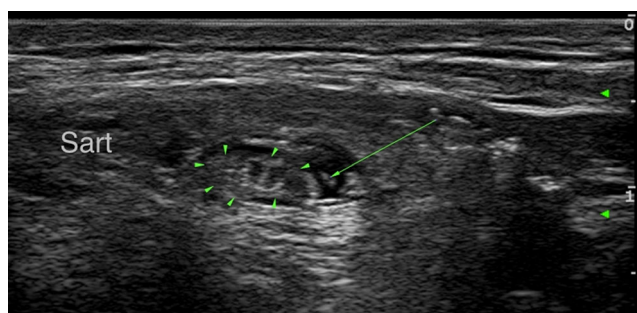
Targeted ultrasound-guided injection around the thickened lateral femoral cutaneous nerve (LFCN). The long arrow shows the echogenic needle tip (out-plane) just adjacent to the nerve coming from lateral aspect in order to spread the medication around and to loosen the perineural tissue by gently advancing the needle more distally. (*Sart*) sartorius muscle
